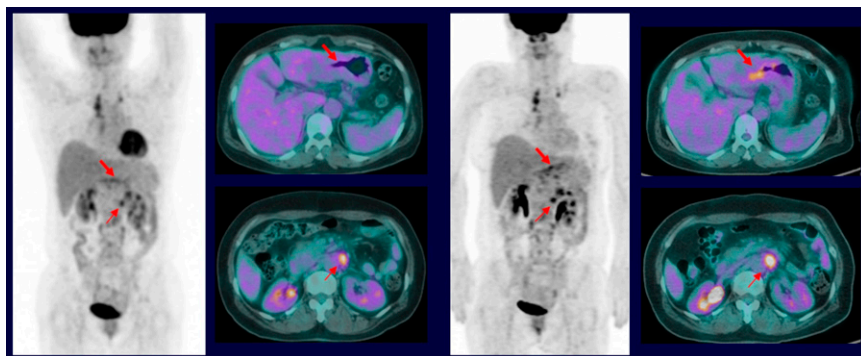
PPAR- γ agonist administration and ^{18}F -FDG PET imaging in a 53-year-old woman with signet ring cell gastric carcinoma and multiple lymph node metastases. Left block: Images acquired 1 day before pioglitazone administration. Right block: images acquired 2 days after pioglitazone demonstrate an increase in SUV_{max} with agonist administration.
